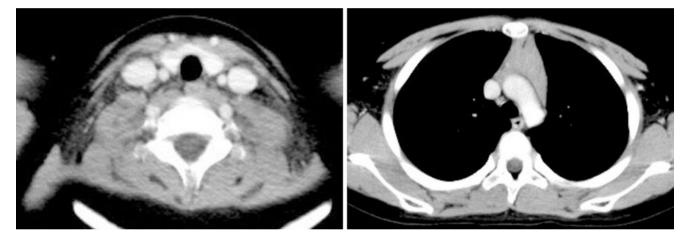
Chest CT showed thymic hyperplasia
